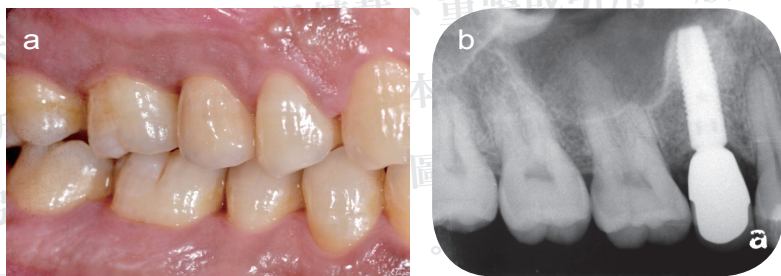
1-year follow (a) buccal intra-oral view; (b) periapical film
